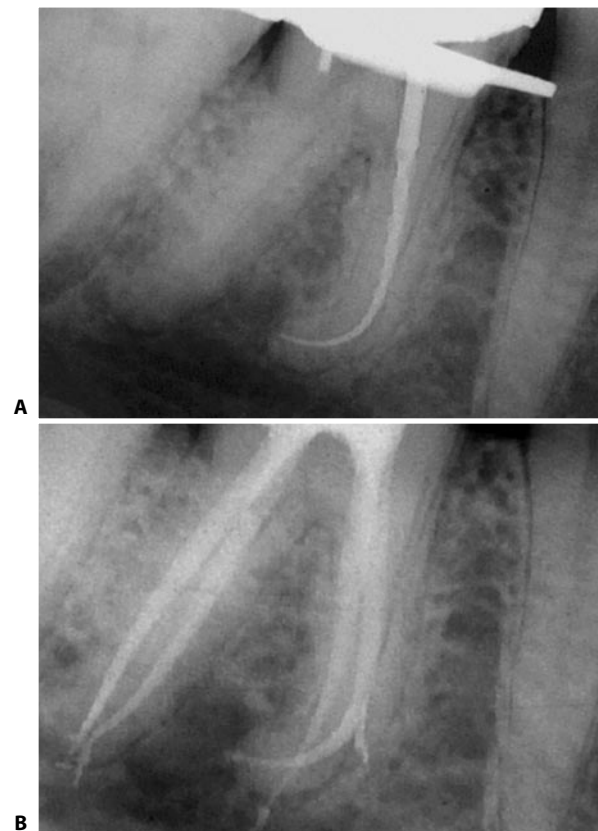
A. 20-.06 GT Hand File cut to length in severely curved mesial canal of mandibular molar. B. Post-operative radiograph.
